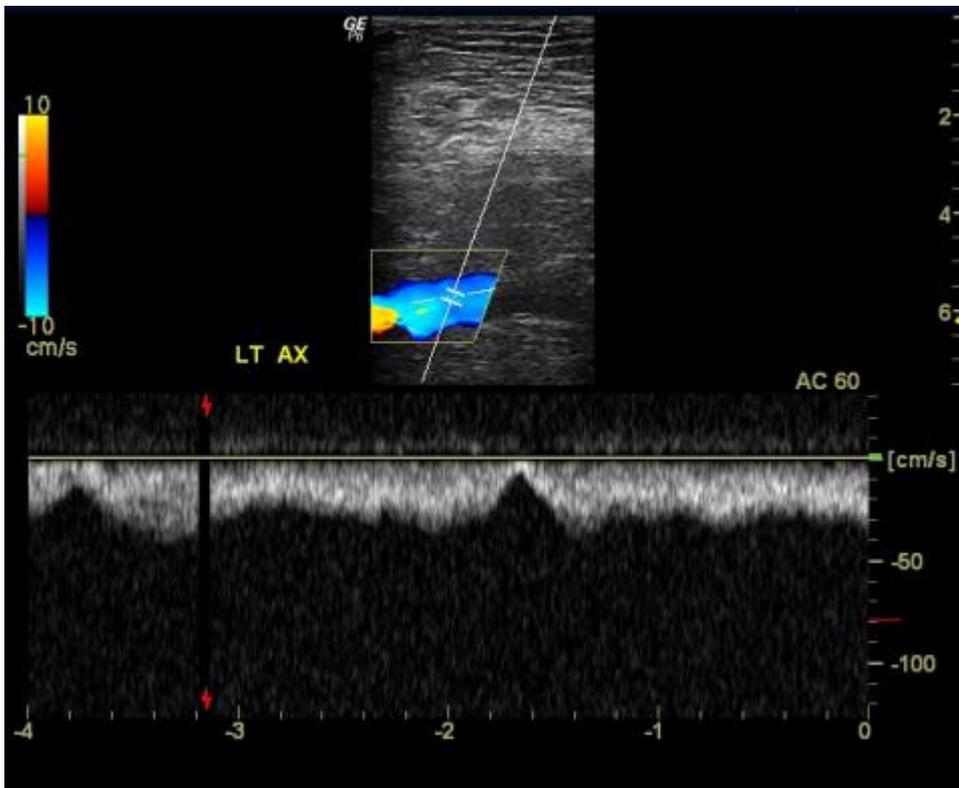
Normal axillary vein spectral Doppler showing phasicity. This suggests not only a patent axillary vein but a patent central system as well.
